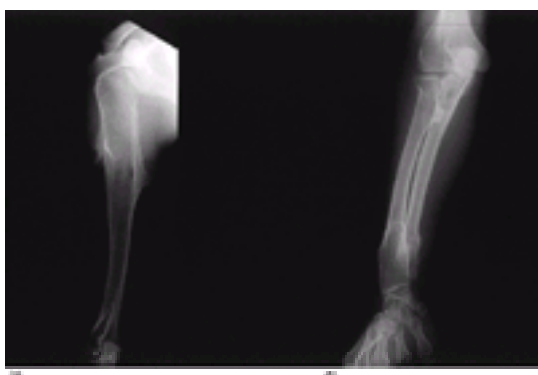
Radiographs of the arm (a) and forearm (b) in a 20-year-old man with hereditary osteochondilaginous exostosis, demonstrating the distortion of the bones, abnormal remodeling of the metaphysis, shortening of the ulna, and multiple exostotic lesions.
